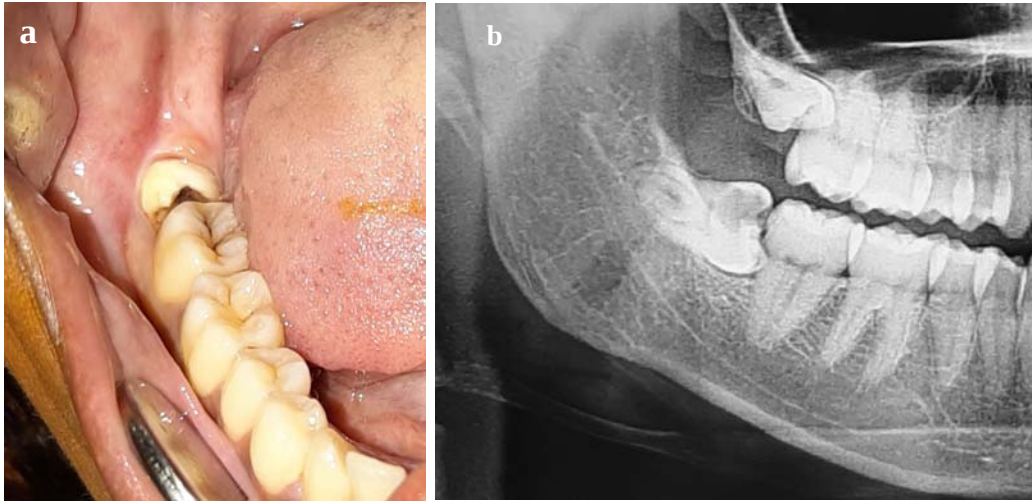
The clinical image (a) and the radiograph (b) show a partially impacted lower third molar. It is important to note that the tooth is partially visible in the oral cavity, with the remaining portion embedded in the bone.
